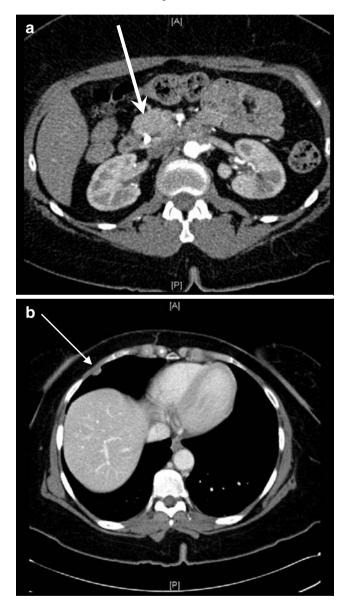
a CT scan image of the pancreatic head mass (*white arrow*). b CT scan image of the pleural nodule in the right middle lobe (*white arrow*).
